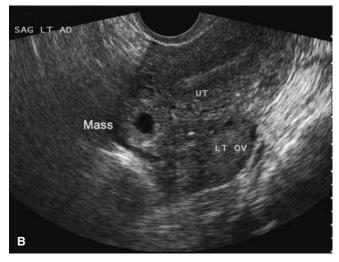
Various transvaginal sonographic findings with ectopic tubal pregnancies. For sonographic diagnosis, an ectopic mass should be seen in the adnexa separate from the ovary and may be seen as: (A) a yolk sac (shown here) and/or fetal pole with or without cardiac activity within an extrauterine sac, (B) an empty extrauterine sac with a hyperechoic ring, or (C) an inhomogeneous adnexal mass. In this last image, color Doppler shows a classic "ring of fire," which reflects increased vascularity typical of ectopic pregnancies. LT OV = left ovary; SAG LT AD = sagittal left adnexal; UT = uterus.
